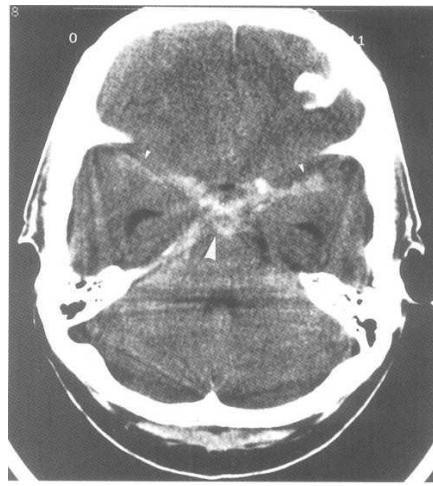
Subarachnoid hemorrhage. This non enhance axial CT brain image demonstrates bright blood in the suprasellar cistern(large arrowhead) and in the Sylvain fissures (a small arrowheads) (Hugue andPatrice, 2002).
